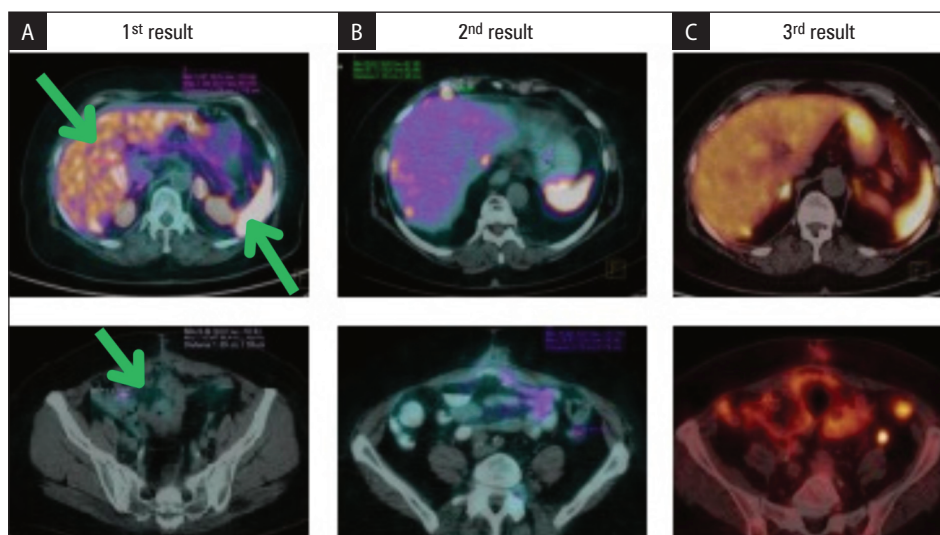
[^{68}Ga]Ga-DOTA-TATE PET/CT of the abdominal cavity and lesser pelvis. A. Visibly increased somatostatin receptor (SSTR) expression in the liver, lymph nodes, peritoneum, and focus in the lesser pelvis (arrows). B. New metastatic foci and implants in the lesser pelvis. C. Stabilization in relation to earlier examinations
